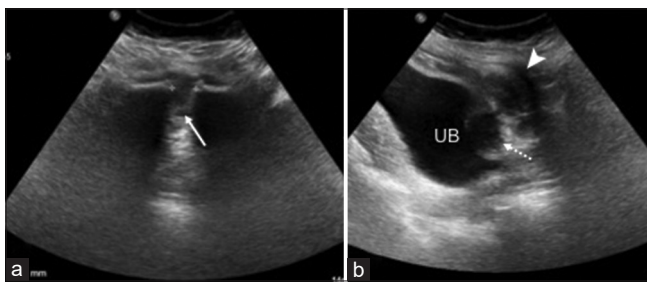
(a) Ultrasonography pelvis in axial plane shows pubic diastasis (white arrow) measuring 13 mm. (b) Sagittal plane shows a rounded hypoechoic lesion (dotted arrow) between the UB and pubic bone (white arrowhead). UB: Urinary bladder.
